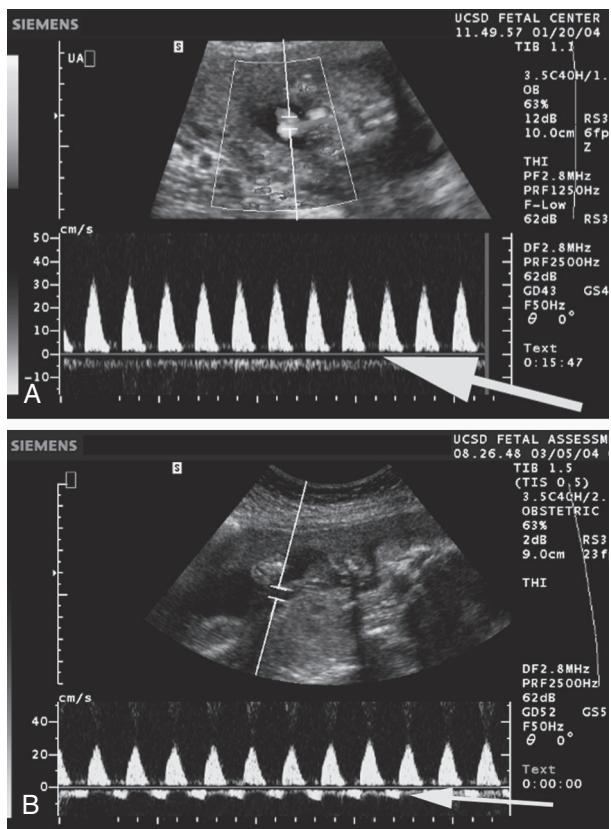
Doppler umbilical artery velocimetry. A, Absent end-diastolic flow. Note the umbilical artery flow velocity waveform returns to zero following each fetal heart beat (large arrow). B, Reverse end-diastolic flow. Here the waveform extends below the zero line (negative flow) between the fetal heartbeats (small arrow).
